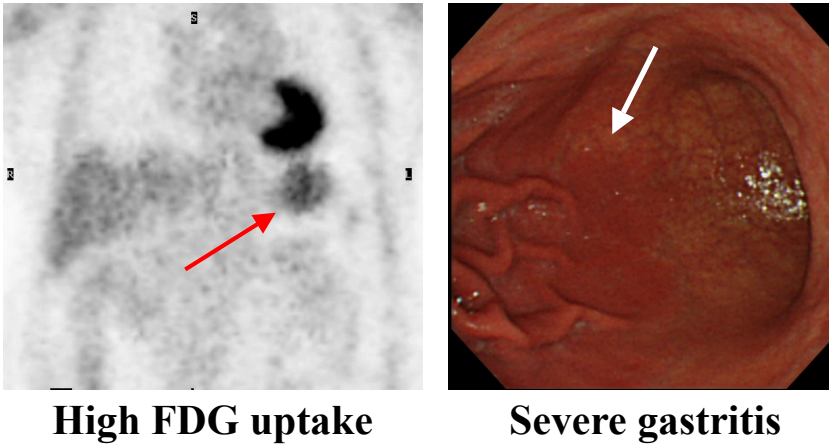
Sixty-seven year-old man showed high FDG uptake and severe gastritis in the upper portion of the stomach.
